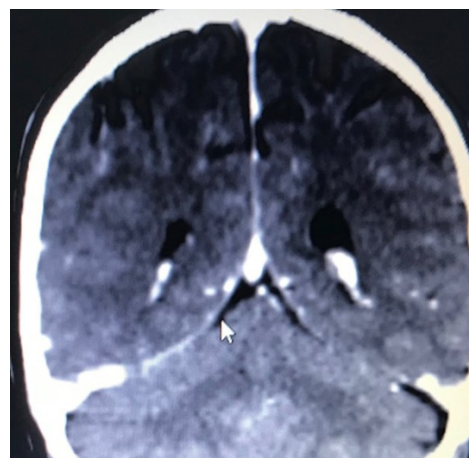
Calcification of the falx cerebri, seen on an axial section of the Brain CT scan. A marked brain atrophy is also visible.
